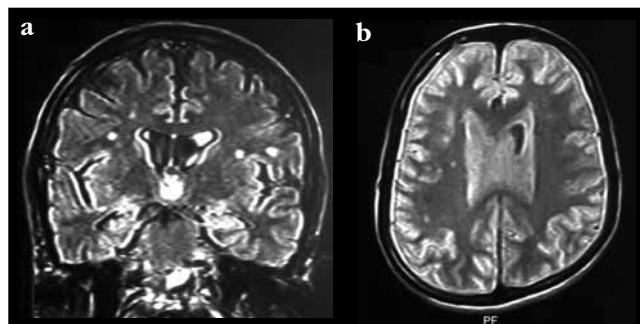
Typical white matter lesions in a 36-year-old male patient with CD and no other risk factors. (a) FLAIR and (b) proton MRI sequences showed bilateral multiple hyperintense white matter lesions
